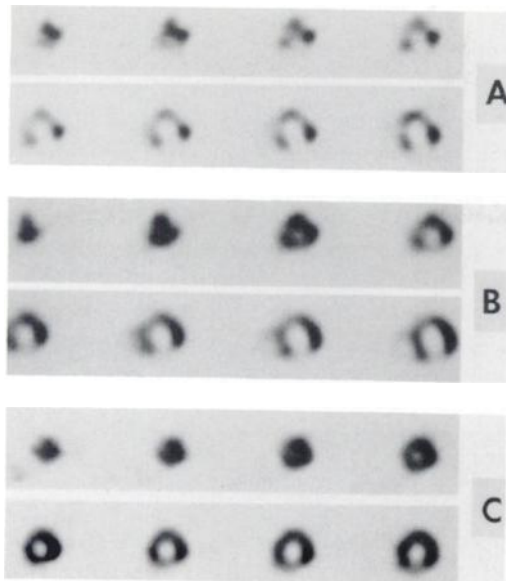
Clinical study—vertical motion postexercise. Shown according to the format of Figure 3, are immediate post-stress (A) and 4-hr delay (C) contiguous short-axis SPECT slices from apex (upper left) to base (lower right) acquired in a clinical study with gross vertical patient motion during the immediate poststress acquisition. Here, obvious defects were improved after applying the motion correction algorithm on the same immediate poststress data. This partially corrected version of images shown in (A) is shown in (B). Postprocessing could not correct motion artifacts in most cases.
